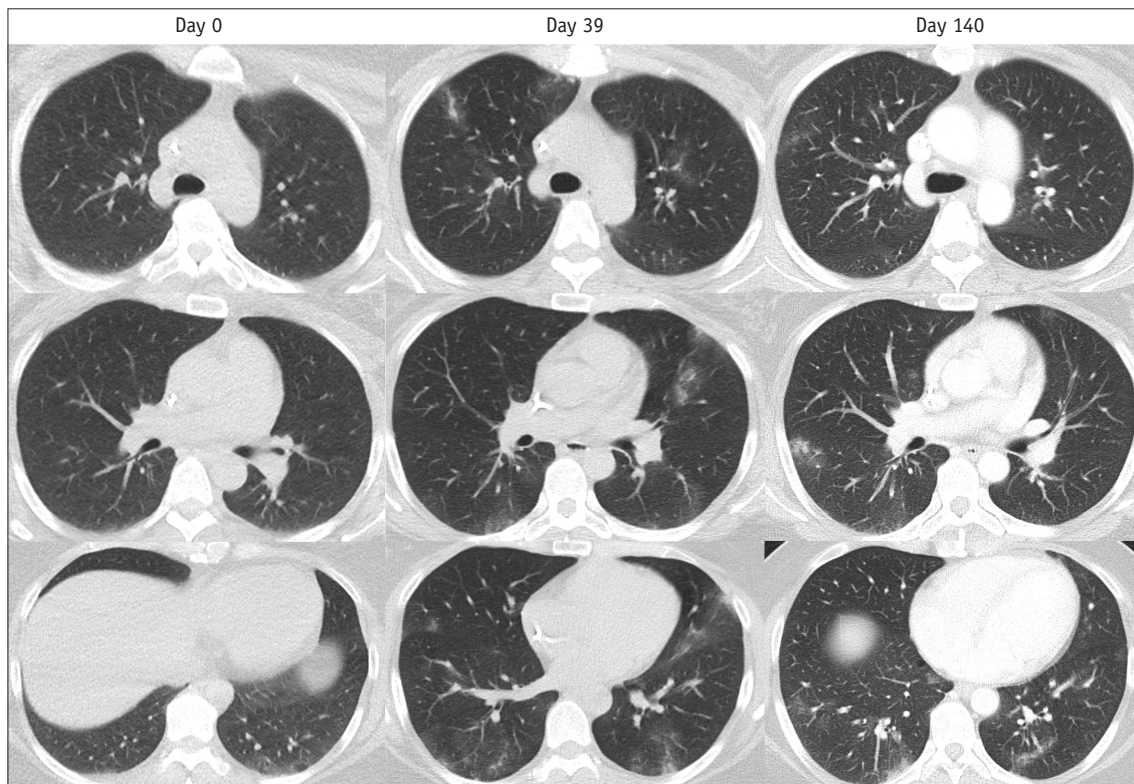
Migratory airspace opacities on serial chest CT images in a 38-year-old female (patient 2) with follicular lymphoma who had received rituximab 17 days prior to COVID-19 diagnosis.
